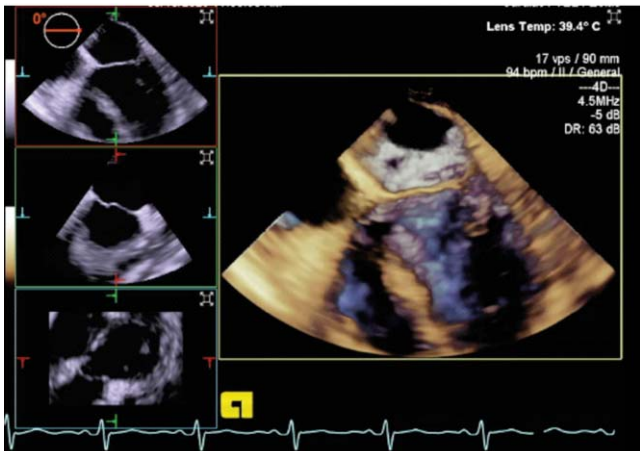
Transesophageal echocardiography showed vegetation attached to chordae of mitral valve.
